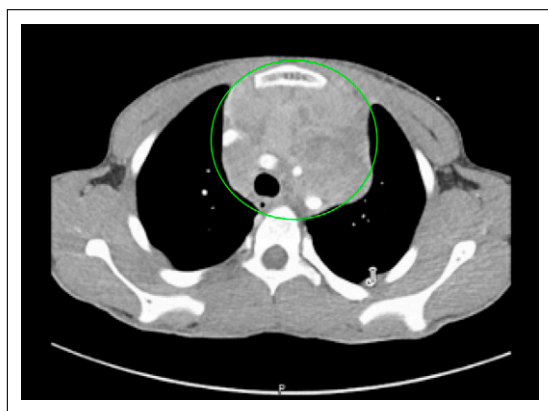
Contrast-enhanced axial computed tomography (CT) imaging of the chest. There is a large, heterogeneous, mildly enhancing mass (circled in green) within the anterior mediastinum. There is mass effect upon the trachea with mild luminal compromise.
